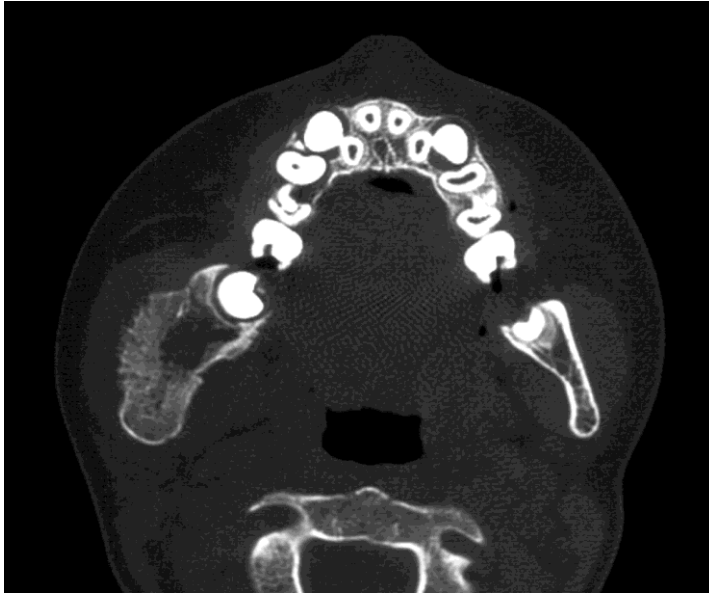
CT of Osteosarcoma of the Mandible.
